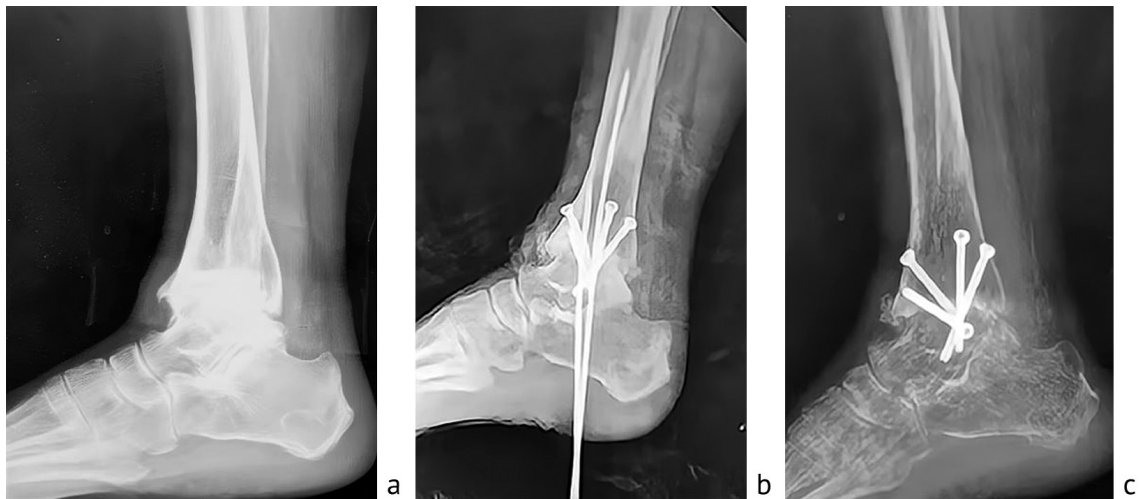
Radiographs of the left ankle joint of a 58-year-old patient (lateral views); dynamics of the arthrodesis process with intraosseous cannulated screws fixation: before surgery (a), 1st day after surgery (b), 3rd month after surgery (c)
